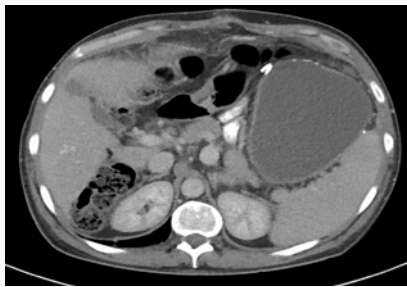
Axial CT on first presentation.
